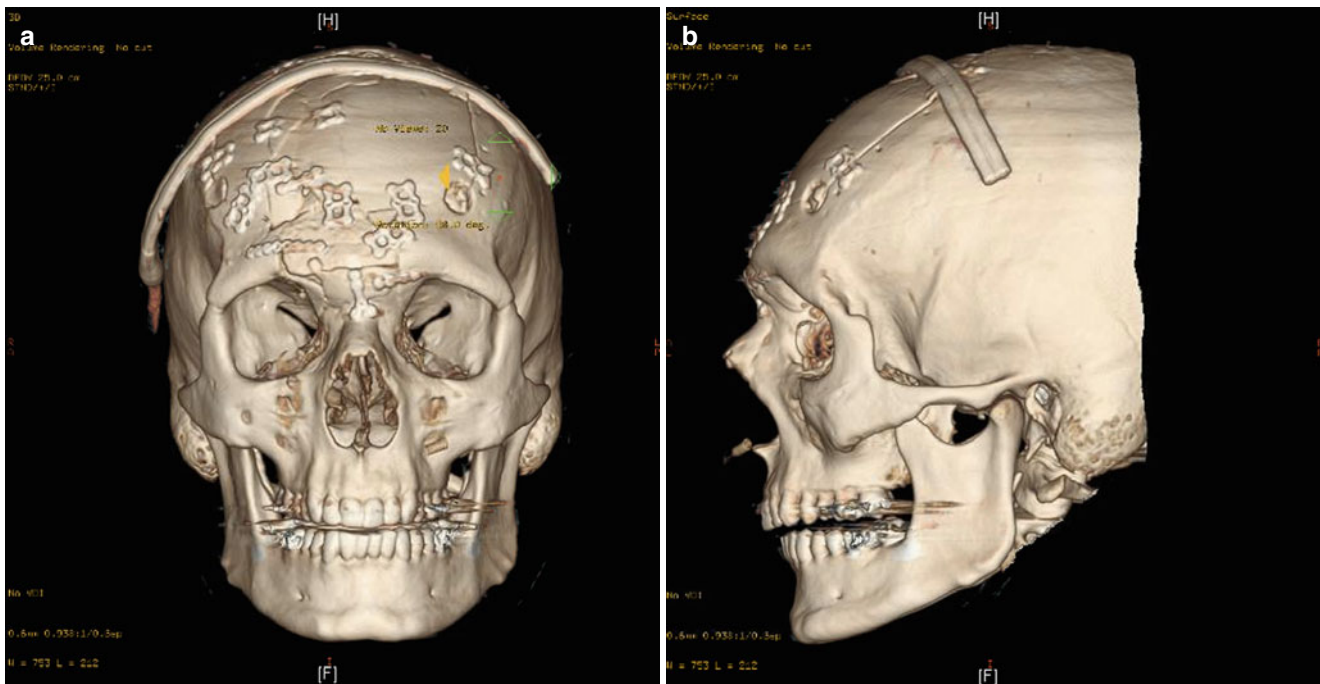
Postoperative imaging: (a) anteroposterior and (b) lateral views of the same patient following computed tomographic scanning and three-dimensional reformatting. A surgical drain is in place. Satisfactory reduction and fixation has been achieved
